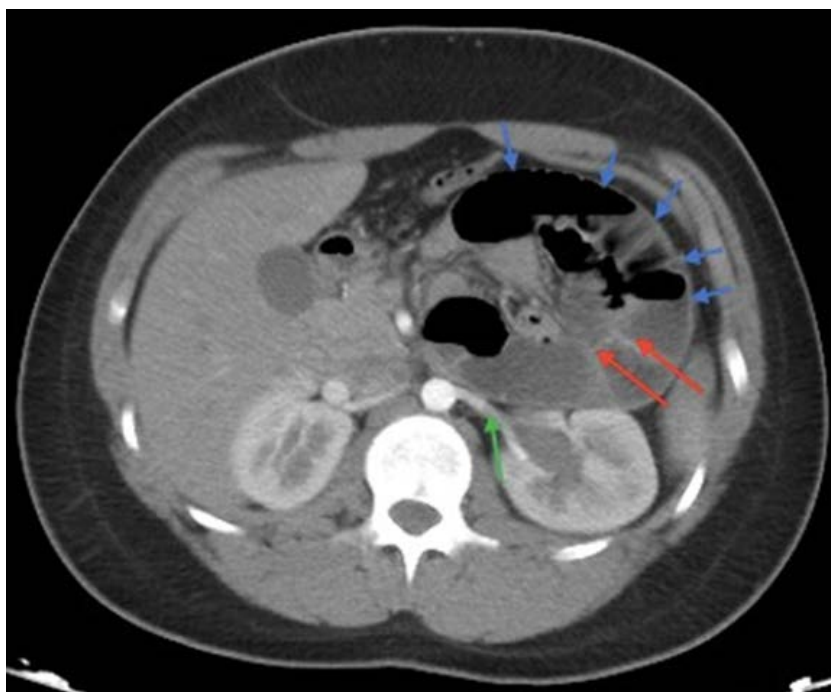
Axial contrast enhanced CT scan of the abdomen showing dilated loops of bowel (red arrows) enclosed within a thin peritoneal membrane (blue arrows) in left abdominal quadrants. Green arrow shows left renal artery posterior to the encapsulated loops of bowel.
